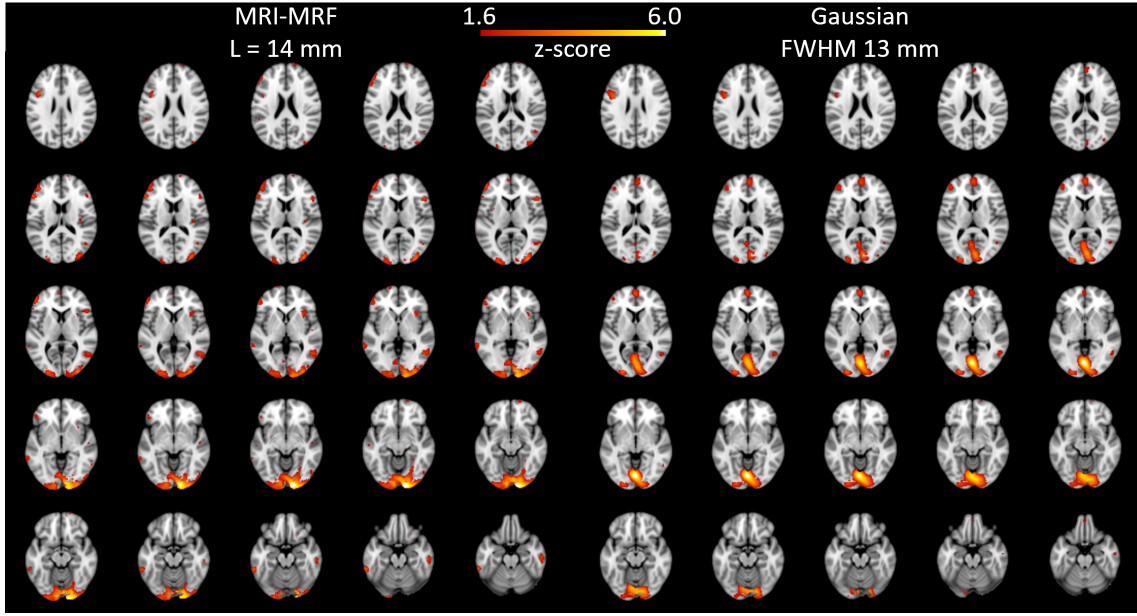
Comparison of brain activation maps across all slices for subject-level analysis with all the fPET frames:  $T_{bin} = 30$  s and  $DF = 1$  for multiple slices. Visual task component across slices for MRI-MRF (left) and Gaussian filter (right) with FWHM 13 mm.
